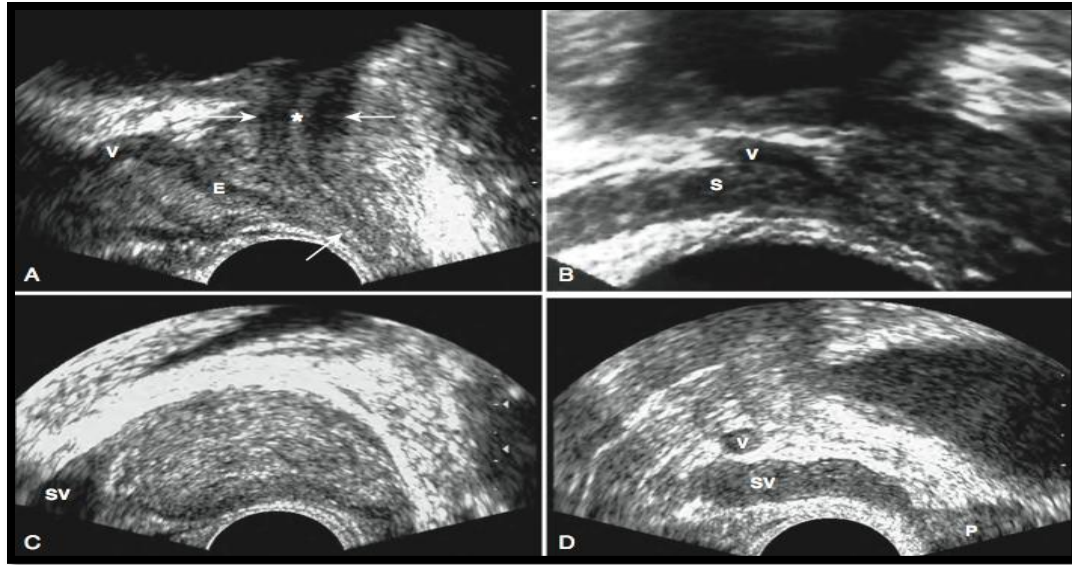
Sagittal Sonographic View Of Prostate Gland
